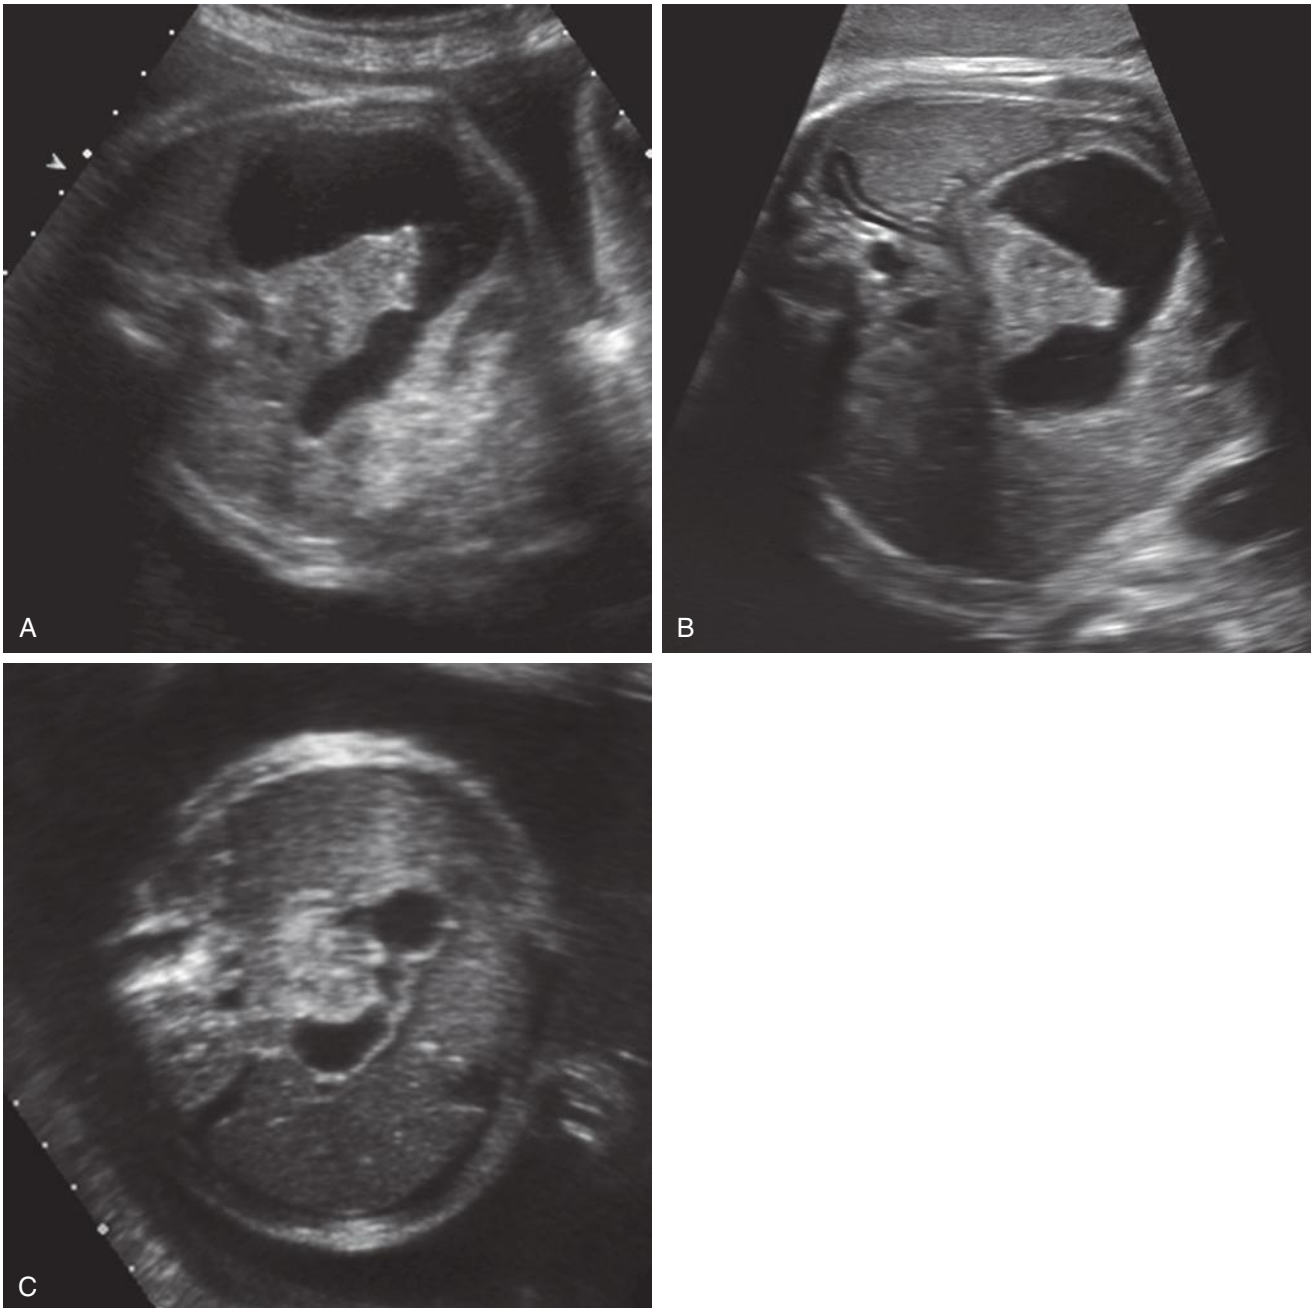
Duodenal obstruction. In these three fetuses the diagnosis of duodenal obstruction was made in the third trimester. All three demonstrate similar, characteristic ultrasound findings with fluid shown in the stomach and proximal duodenum. A, This fetus was first seen at 34 weeks. On postnatal evaluation, he was found to have an annular pancreas and normal chromosomes. He is doing well except for gastroesophageal reflux. B, Duodenal atresia in a fetus with Down syndrome. C, This pregnancy was followed for mild fetal ascites (see Fig. 14-18). Evidence of duodenal obstruction and mild polyhydramnios was noted by ultrasound examination at 31 weeks. The child has Down syndrome and underwent an open duodeno-duodenostomy on day 9 of life.
